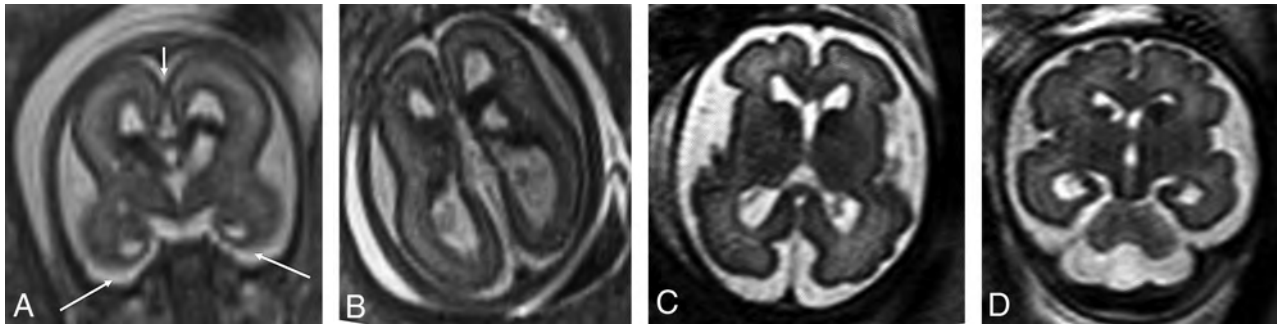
TUBA1A* mutations (A–C). Case 18. T2-weighted single-shot FSE at 24 weeks 4 days' gestation. *TUBA1A* pathogenic heterozygous variant. The bilateral GEs are enlarged. The fronto-occipital diameter is 2.5, standard deviations below the mean. The corpus callosum and cerebellum are severely hypogenetic/hypoplastic. Underopercularization, severe ventriculomegaly, a thin kinked brainstem (A), a ventral pontine cleft suggestive of a Walker-Warburg phenotype, and apparent diencephalic-mesencephalic fusion or dysplasia (C) are also noted. D, Case 19 at 33 weeks. *TUBA1A* mutation with enlarged, cavitated GEs and abnormal persistence of hemispheric lamination.
